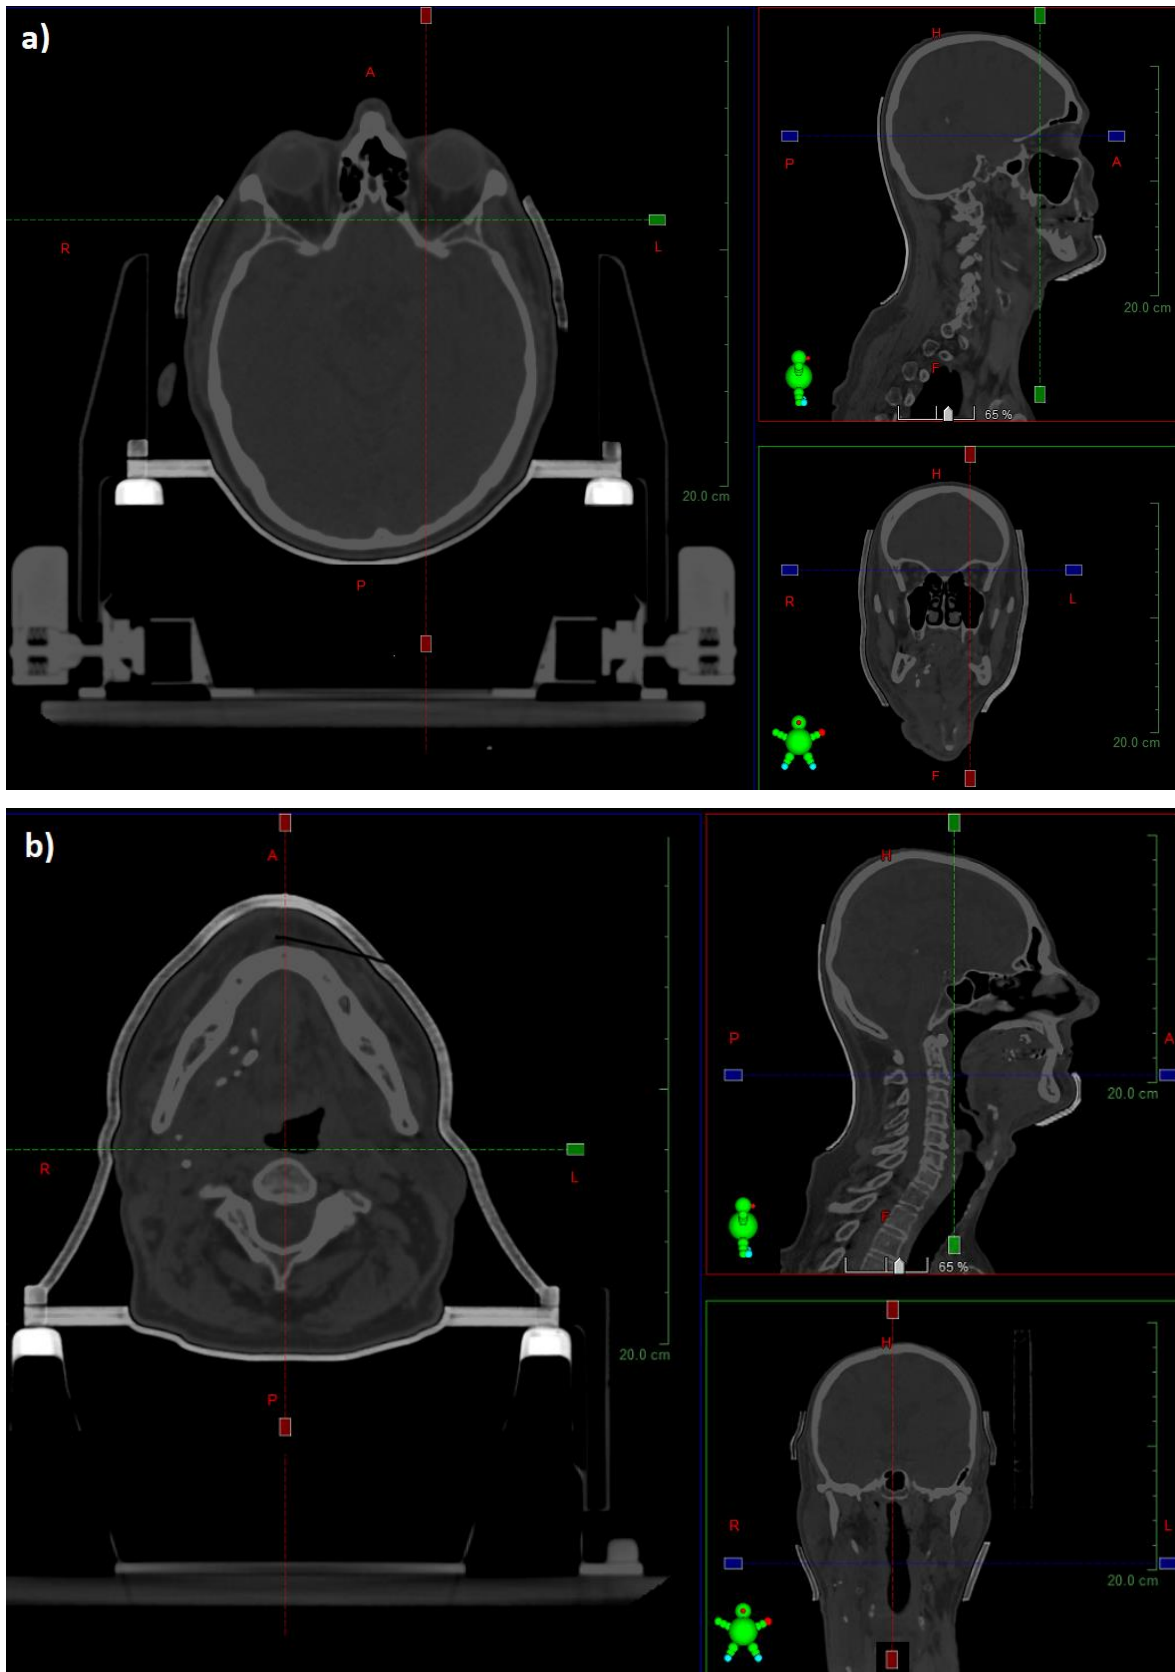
Visualization of the study planning CT of patient B, blended with the CBCT of the 3D printed immobilization as used for the quality assurance prior to the first usage. The visualized regions are the temporal bone region (a) and the mandible region (b).
